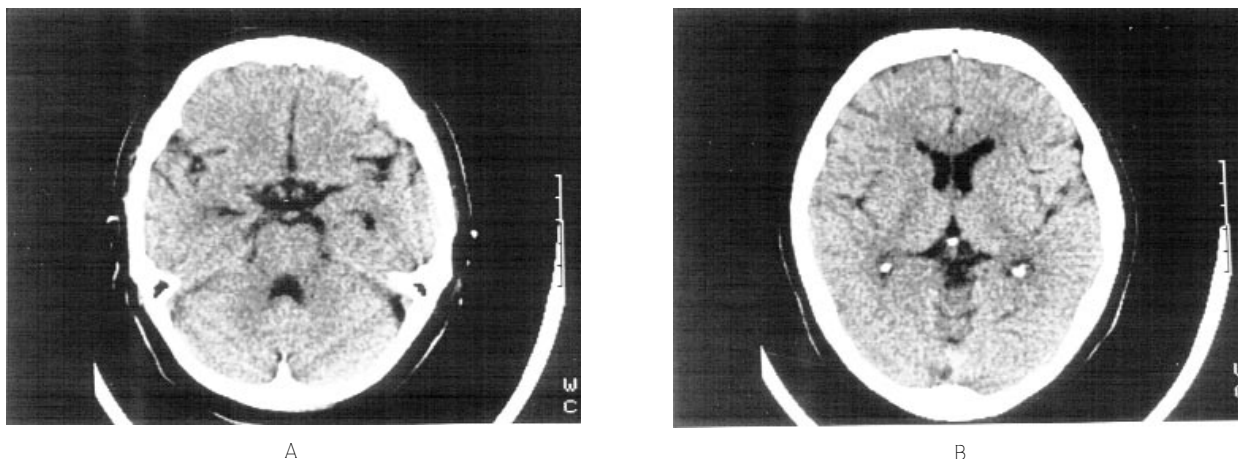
Axial CT scans (A-B) taken 12 days after the prolonged anoxia show mild diffuse hypodensity in white matter, especially in the periventricular region of the anterior horns.
